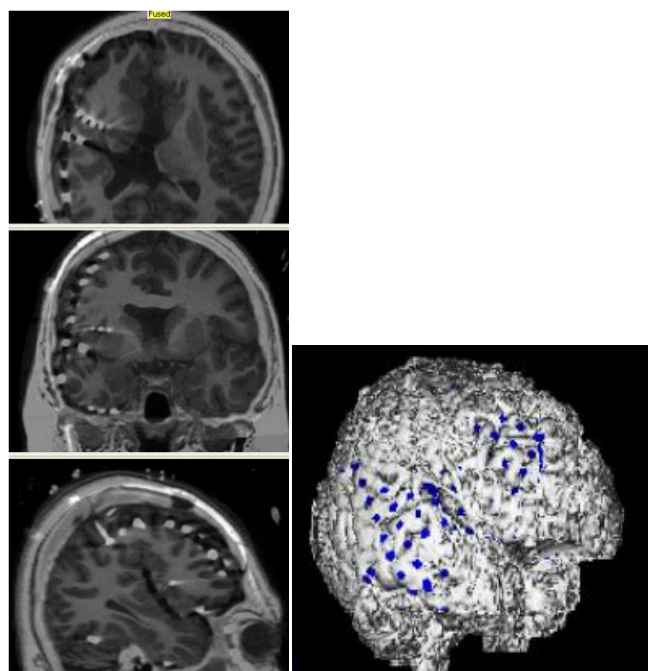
Postoperative CT/MRI showing electrode placement
